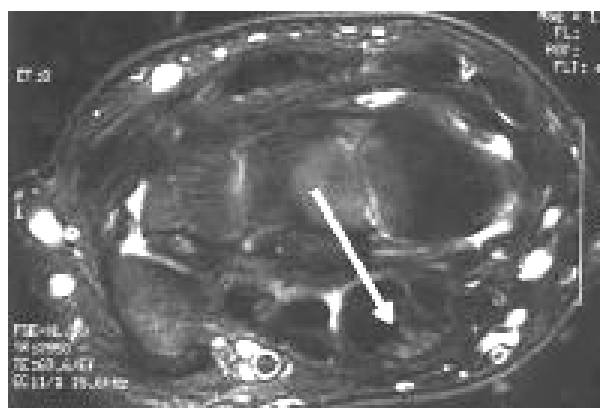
Normal findings of isointense-to-hypointense appearance of the median nerve on fast spin-echo T2-weighted MRI (arrow). Note the fairly well-defined nerve fascicles within the median nerve sheath (Balci and utku, 2007).*
